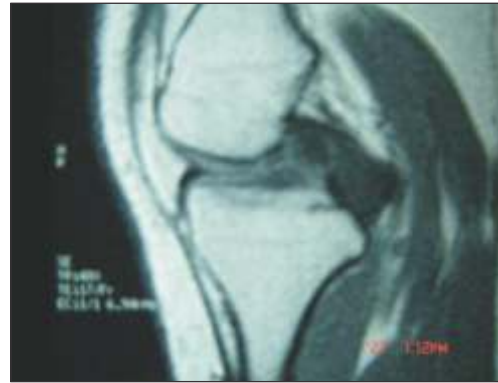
MRI showing soft tissue mass on T2 images overlying anterior aspect of posterior cruciate ligament.
